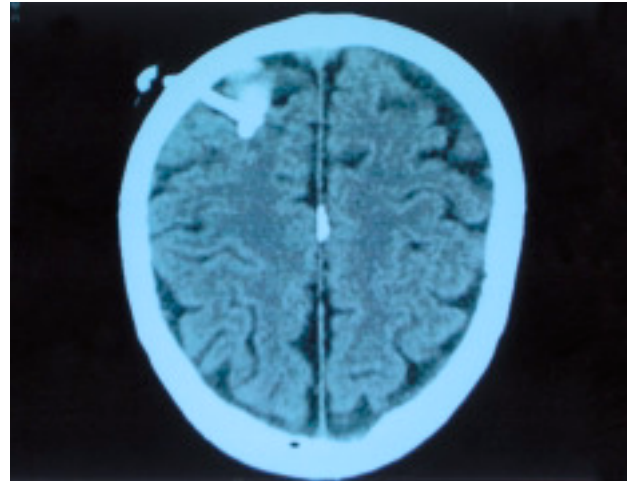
Cranial CT image after drainage of the cystic tumor.
